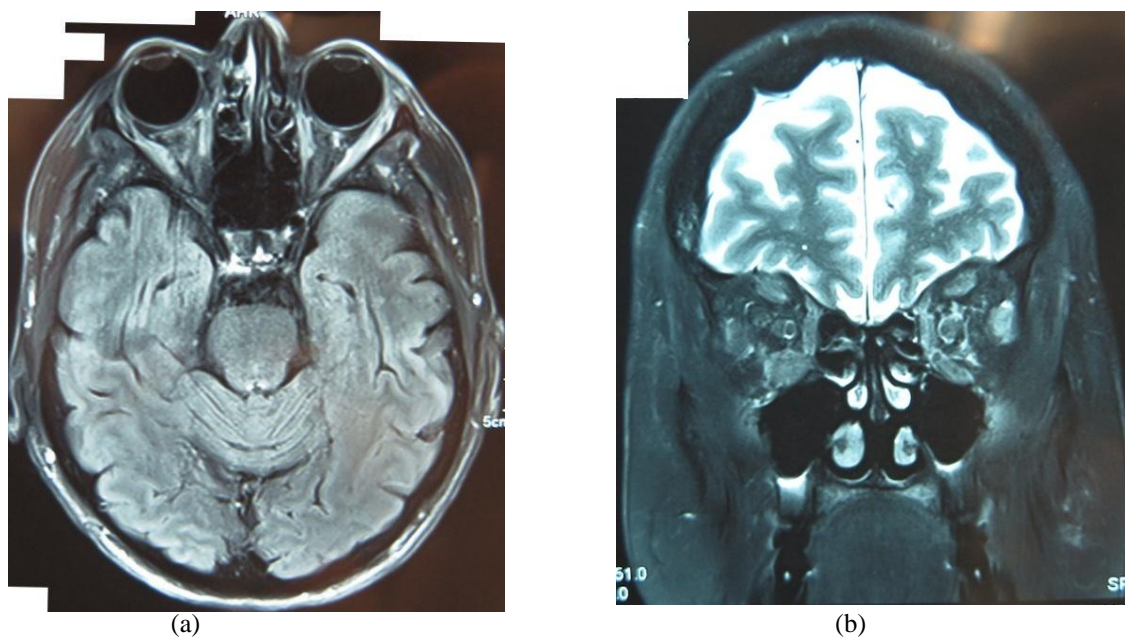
MRI scans showing bilateral extraocular muscle enlargement due to breast cancer metastases. Figure (a). Coronal view; (b). Transverse view.
